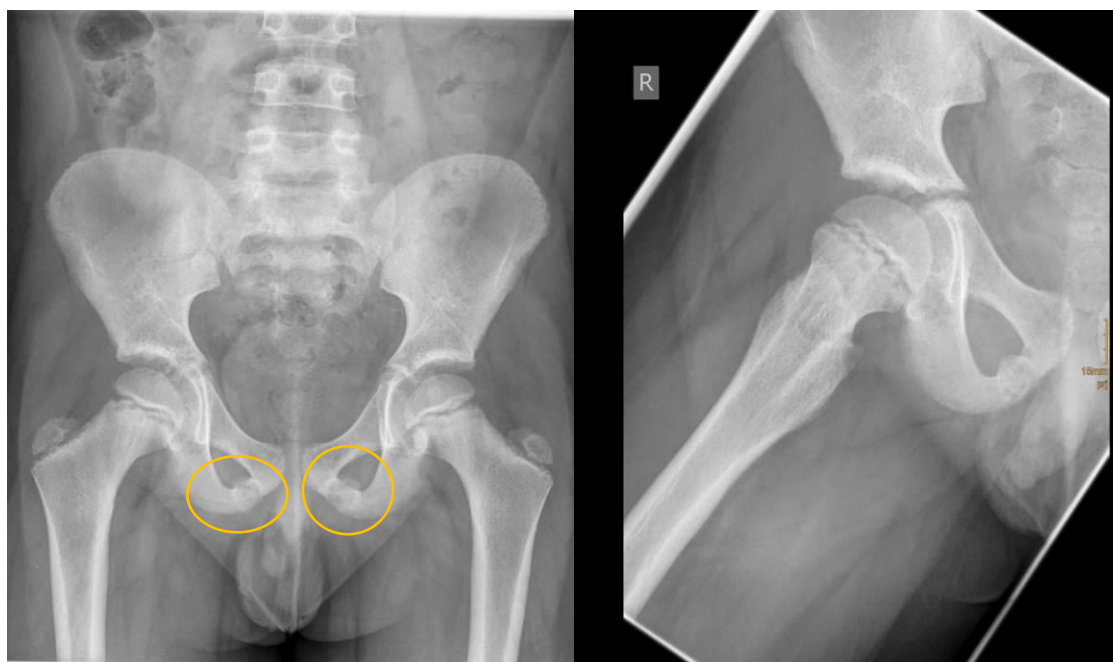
Radiographs of the pelvis and the right hip.
